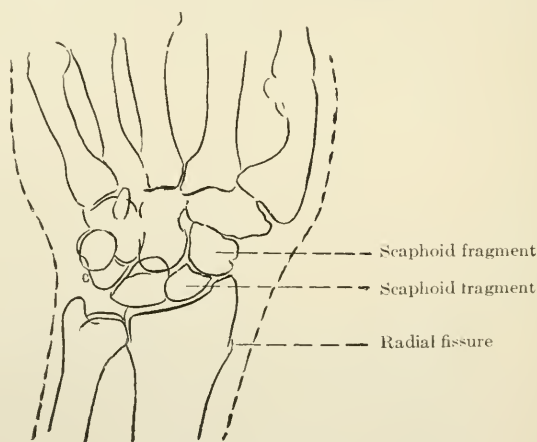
Case. Fracture of the scaphoid and fissure of radius (*x-ray* tracing) (Balch) (Scudder).
